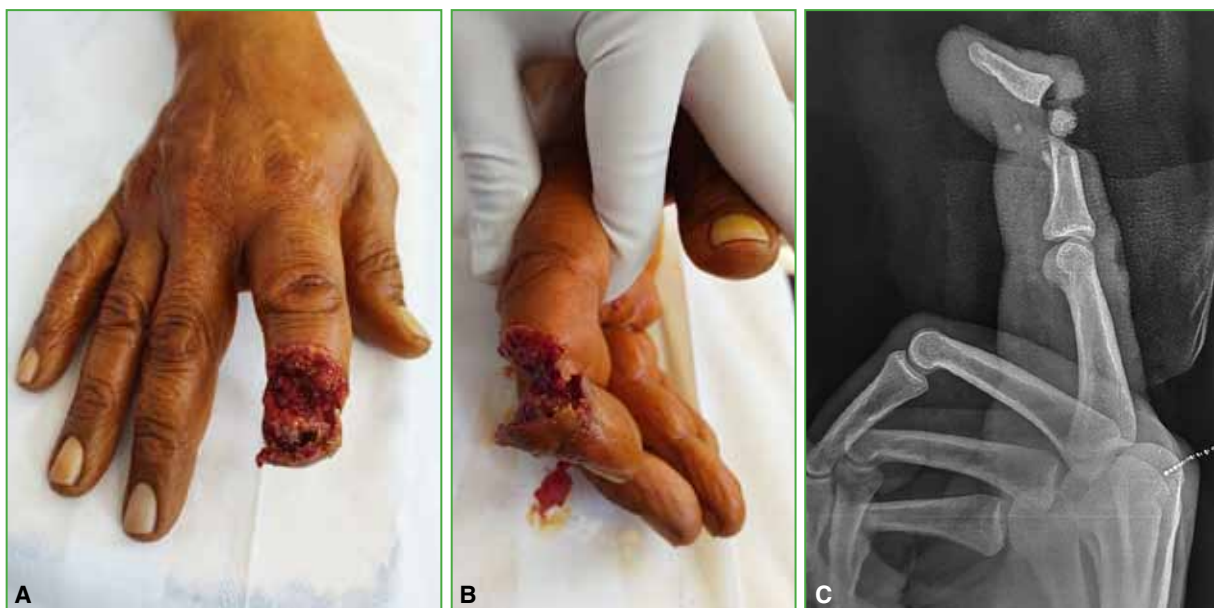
A. Serious injury to the index finger of the right hand, dorsal view. B. Serious injury to the index finger of the right hand, lateral view. C. Radiograph of the index finger, lateral view. A fracture of the second phalanx is observed.
